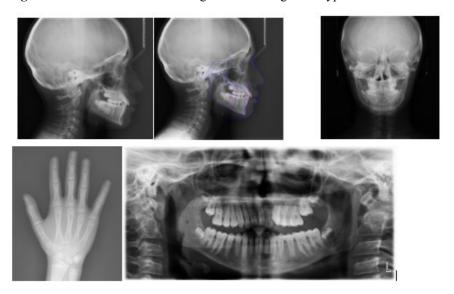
Radiographic Figures Following Petit-Type Face Mask Use
